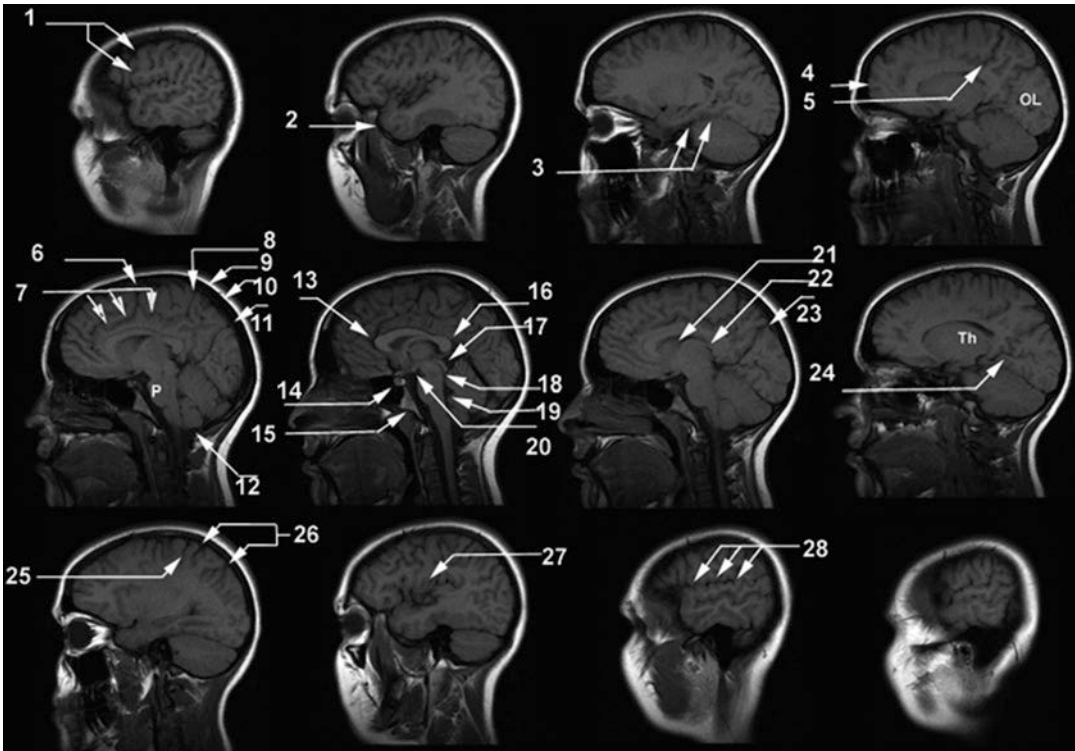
Sagittal T1-weighted MR images. (1) Central sulcus, (2) temporal pole, (3) parahippocampal gyrus, (4) frontal pole, (5) ascending branch of cingulate sulcus, (6) mammillary body, (7) cingulate sulcus, (8) ascending branch of cingulate sulcus, (9) scalp, (10) calvarium, (11) superior sagittal sinus, (12) cerebellar tonsil, (13) genu of the corpus callosum, (14) pituitary gland, (15) clivus, (16)
